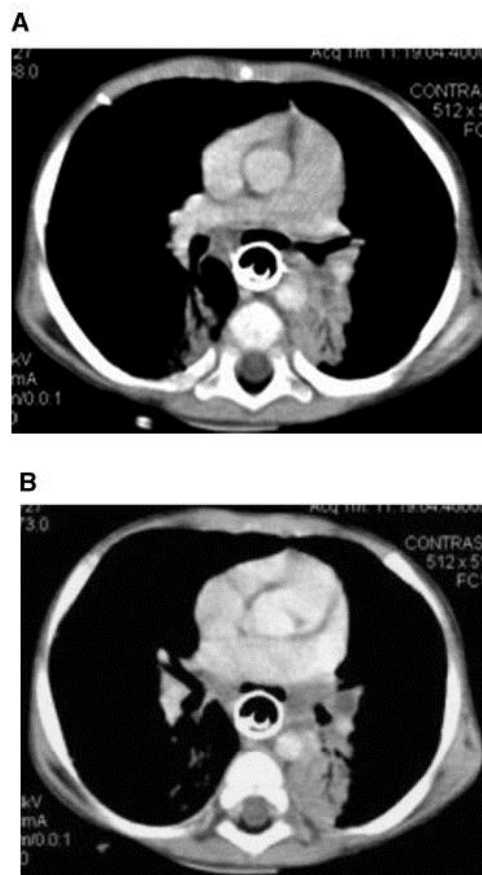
A, B: Axial, consecutive CT scans below the level of the carina demonstrate air anterior to the esophageal stent inferring a fistulous communication between the esophagus and left main bronchus. Left hilar and subcarinal lymphadenopathy is present as well as posterior segment air-space disease bilaterally.
